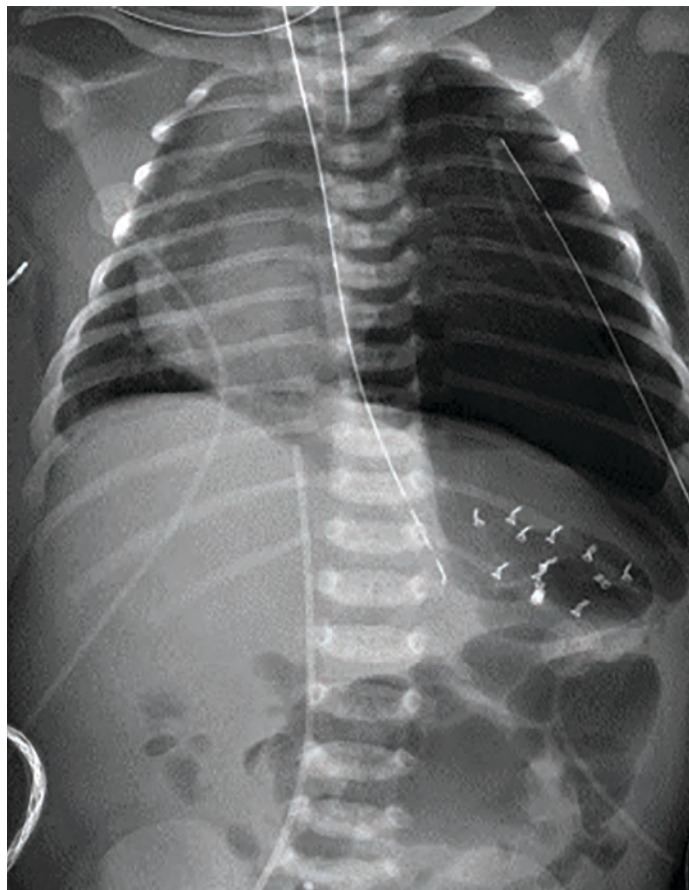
Follow-up chest radiograph shows the postoperative changes of the left hemidiaphragm, dextrocardia, or cardiac rotation secondary to the CDH, and a left-sided chest tube
